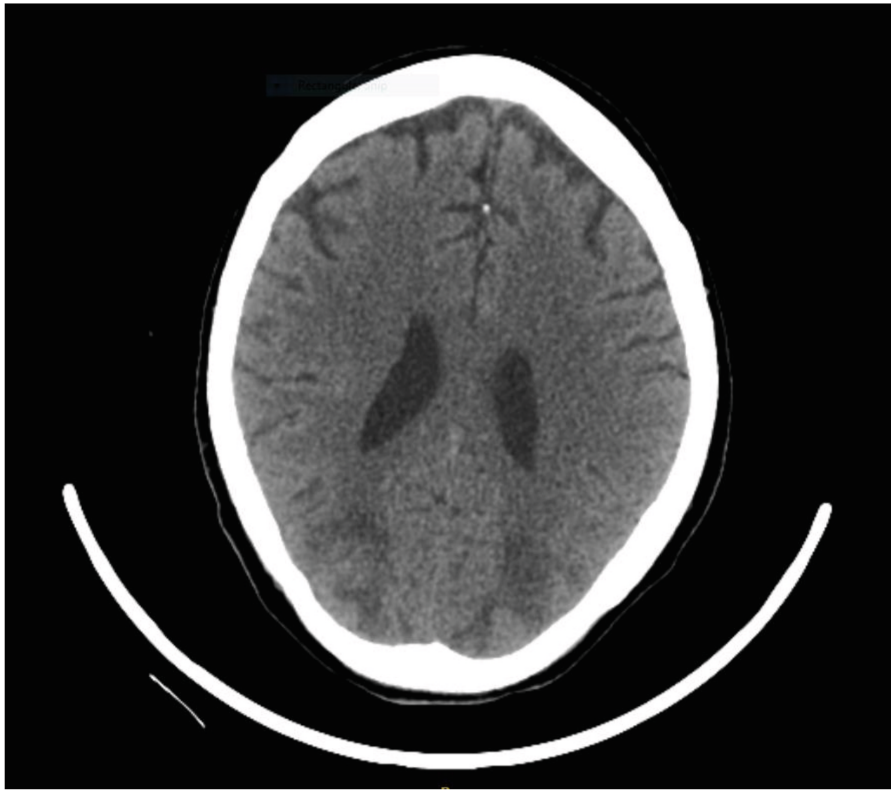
Initial CT brain showing hypodense changes in the bilateral parieto-occipital regions.
